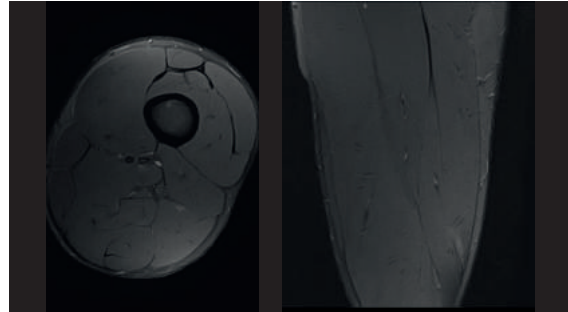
(Case #7): Myoaponeurotic strain in the deep zipper of the long head of the femoral biceps muscle. MRI signs included interstitial oedema and minimal intermuscular fluid/haemorrhage.
